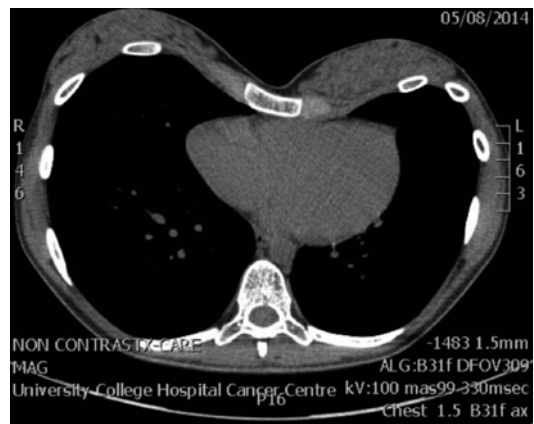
CT scan with tilt of sternum with depressed right side
